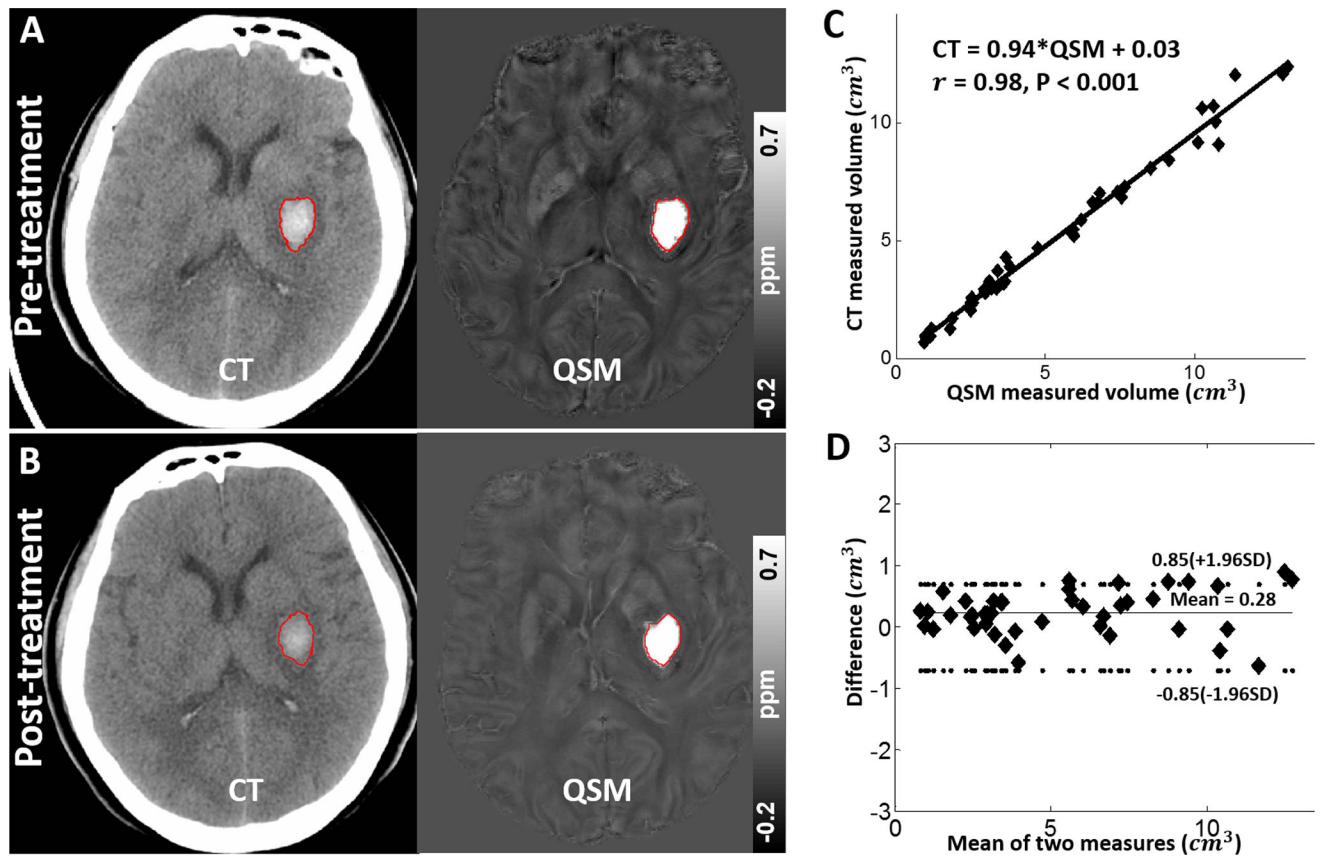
(A) & (B) Comparison of QSM versus CT for hemorrhage volume measurement. (C) Regression of volume measurements on QSM versus CT in all patients. (D) Comparison analysis of volume measurement on CT versus QSM images using Bland-Altman plot.
